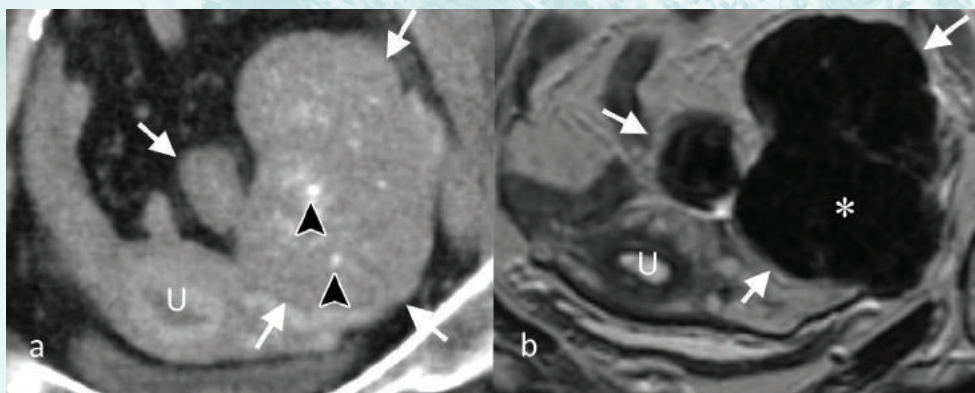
Brenner Tumour: (a) CT scan through a left ovarian mass (white arrows) that contains calcifications (arrowheads). (b) T2-w MRI scan showing large low signal areas in the mass (*) indicative of fibrous tissue. (U – uterus).
